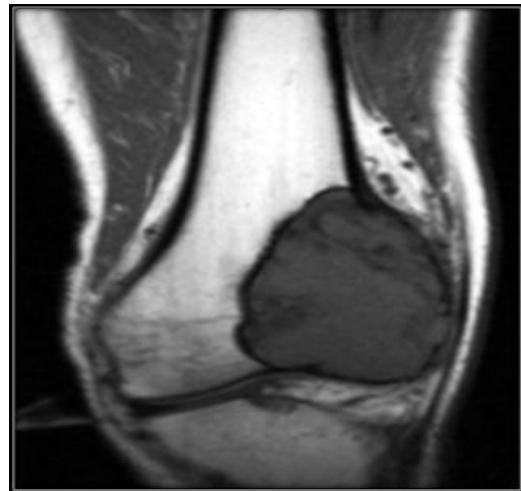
T1 weighted coronal MR image reveals the expansile hypointense lesion in the subarticular location of distal femur.
